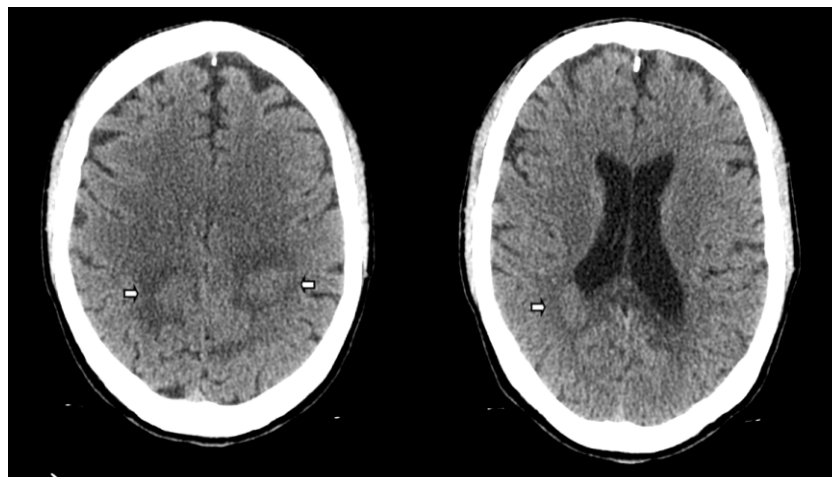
Two CT axial images demonstrate a slightly hyperdense mass with adjacent edema involving the parietal white matter (first image arrows) and the splenium of the corpus callosum (second image arrows).
